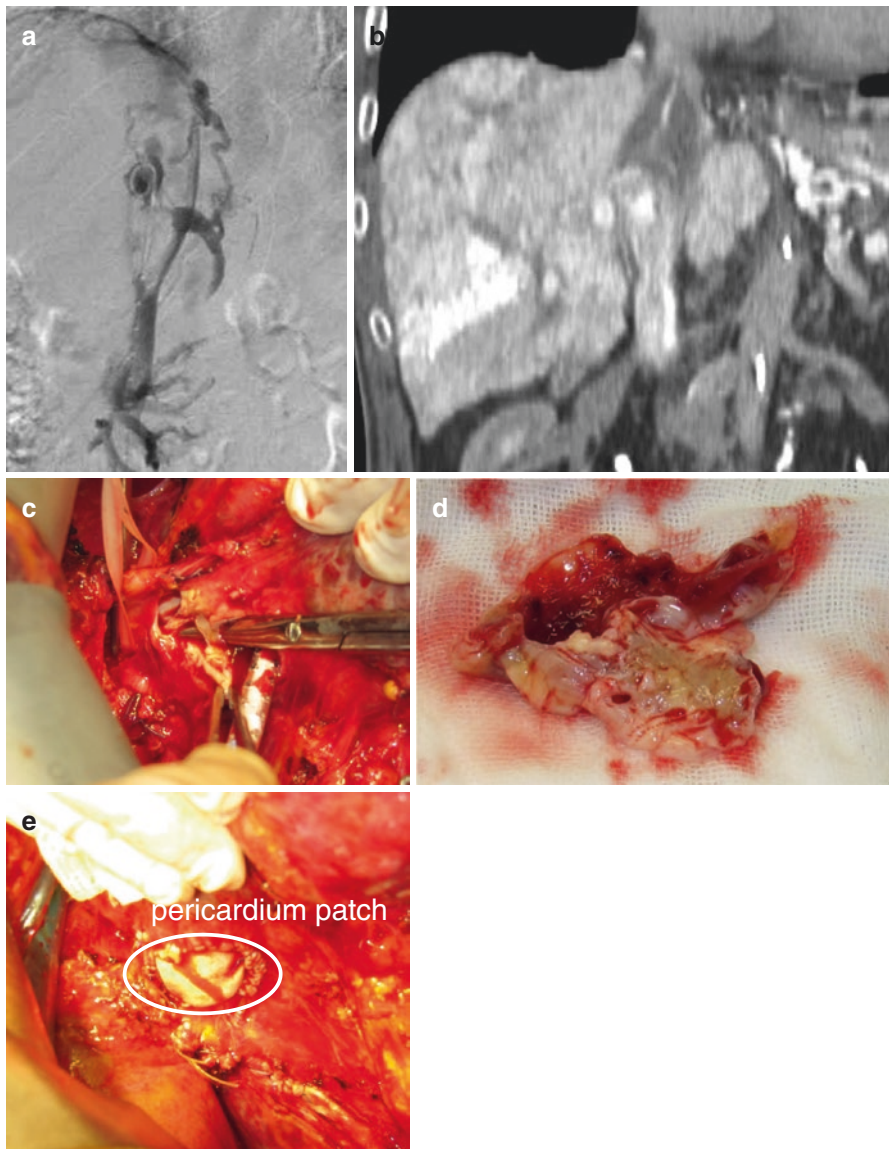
Surgery for BCS in our case. (a) Angiography showed IVC obstruction. (b) CT showed thrombus and obstruction in the IVC. (c) Thrombectomy from IVC. (d) Obstructive membrane, (e) Patch plasty by a pericardium patch
